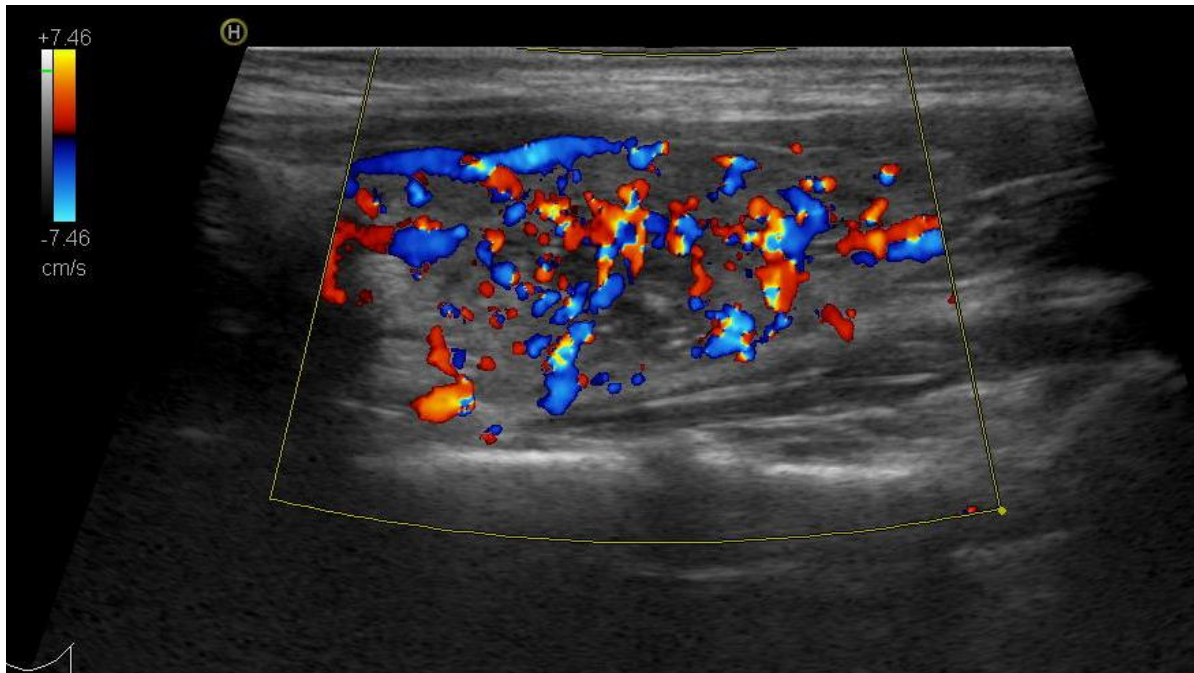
Nodular thyroid gland formation with enhanced peri and intranodular vascularization in color Doppler mapping
